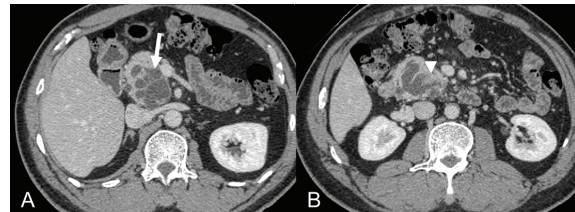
A 54 year-old male with chronic abdominal pain and history of chronic pancreatitis. The axial post contrast CT scan showed multilocular macrocystic lesion at head of pancreas (arrow in A) with enhancing mural nodule (arrowhead in B). Diffused main pancreatic duct dilatation is observed (not shown). The pathology from Whipple operation revealed intraductal papillary mucinous neoplasm with borderline malignant potential
